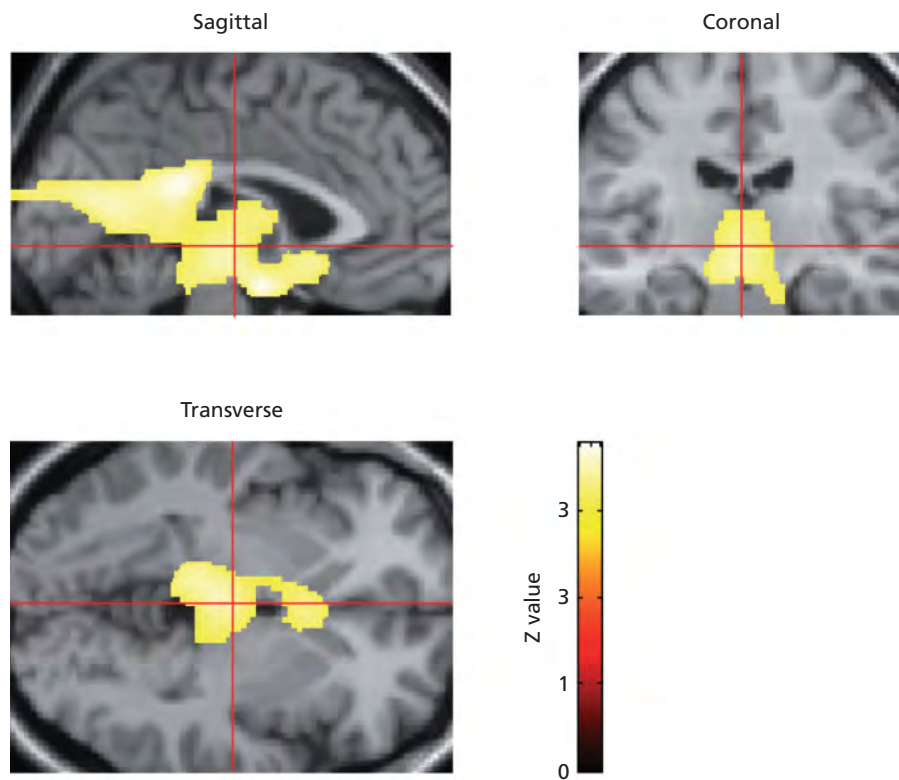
FDG-PET scan showing hypometabolism in Korsakoff patients with significant reduction of signal in thalamus, ventromedial cortex and retrosplenium. (From Reed *et al.* 2003. Courtesy of Professor M. Kopelman, St. Thomas' Hospital.)
